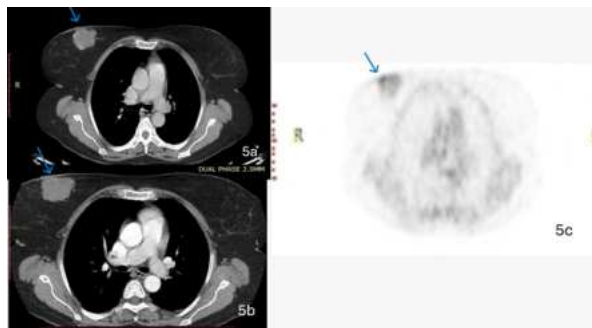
PET CT (5a,5b&5c) showed uptake of FDG in the lobulated mass with mass showing persistent enhancement in delayed scans. No evidence of any axillary nodes or distant metastasis.
